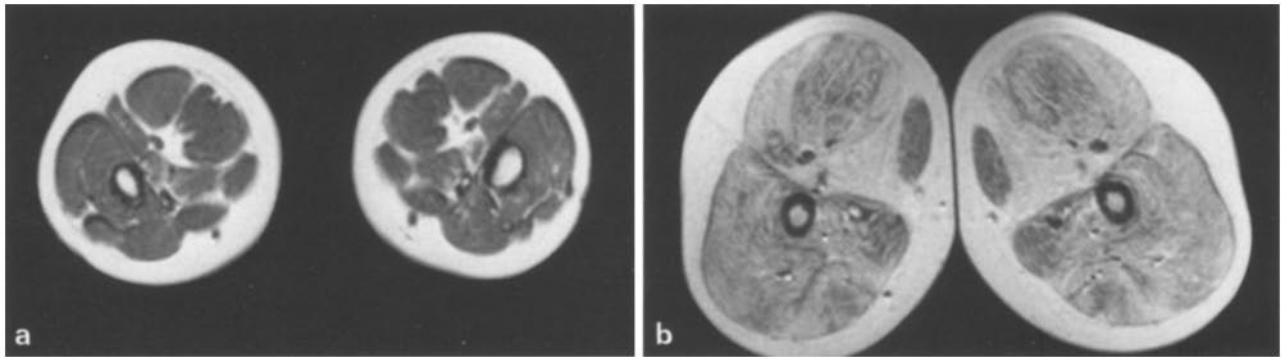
Comparison sections through the thigh in two patients with DMD. a was clinical stage 1-2. b was clinical stage 5 at time of MR image acquisition. Note the selective muscle pathology and lesser degree of fatty infiltration in the earlier stage
